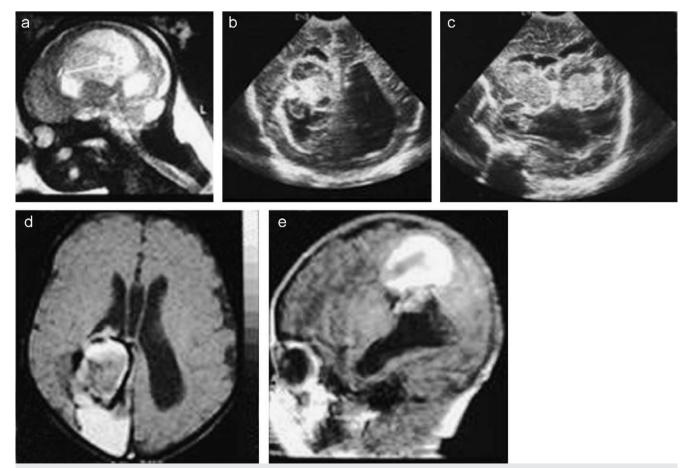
Patient No. 9: Prenatal T_2 -weighted MRI image at 36 weeks of gestation (a), neonatal coronal and sagittal cranial ultrasound (b, c) and neonatal axial and sagittal T_1 -weighted MRI images (d, e). Images show the prenatal intraventricular haemorrhage complicated by a periventricular venous infarction partially cavitated communicating with the ipsilateral ventricle.
